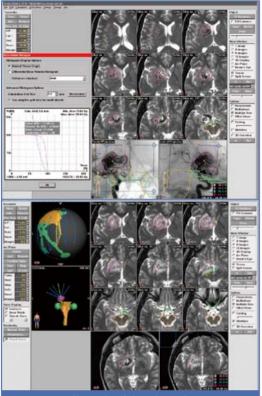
A small 4.2ml Left basal ganglia AVM was treated by SRS, 17 Gy was delivered to AVM margin. Follow up MRI & angiogram showed obliteration of AVM.
